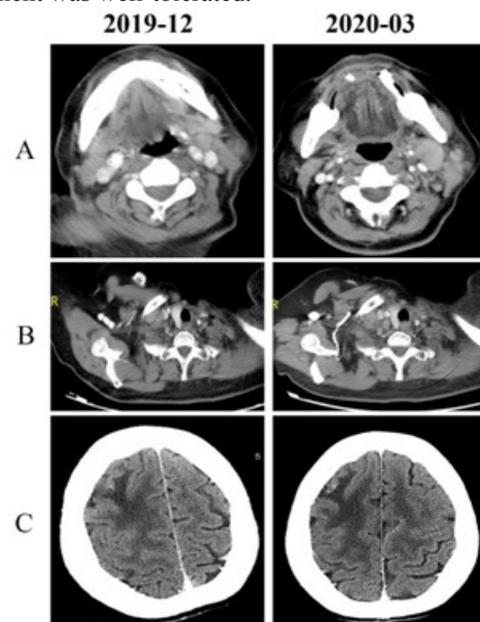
Enhanced CT scan before and after the 2 cycles of the treatment of gemcitabine and carboplatin. The left cervical lymph node (A) and the right supraclavicular lymph node (B) enlarged while the metastatic brain lesion (C) was stable. CT, computed tomography.
